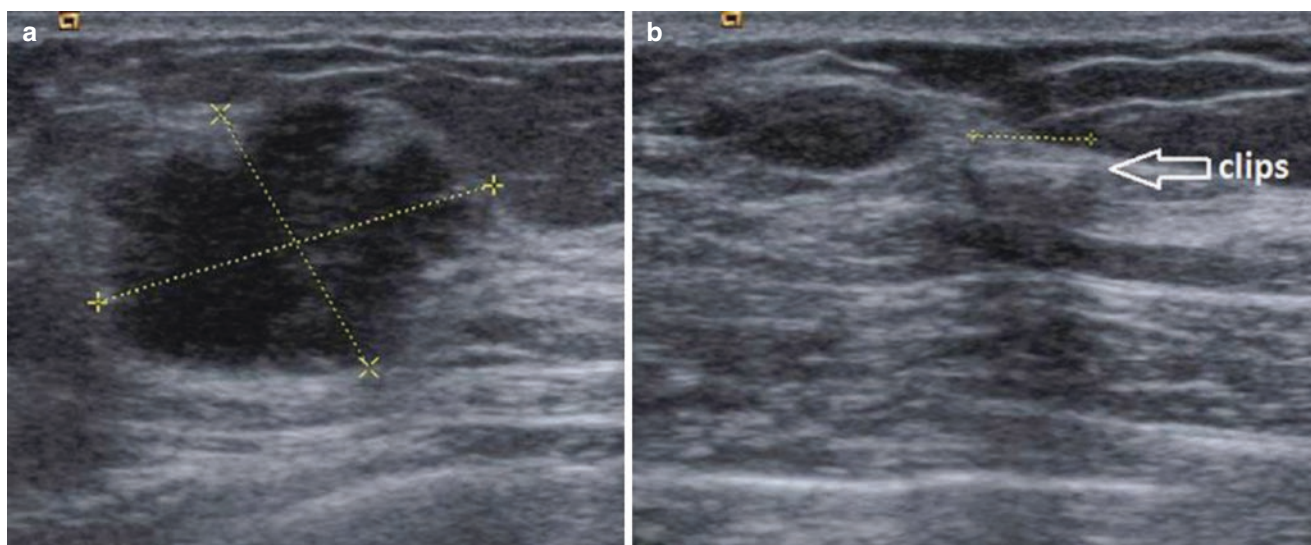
Ultrasonographic imaging of the patient before (a) and after (b) PST with complete pathological response. Titanium clip for tumor bed localization is also seen in ultrasound
